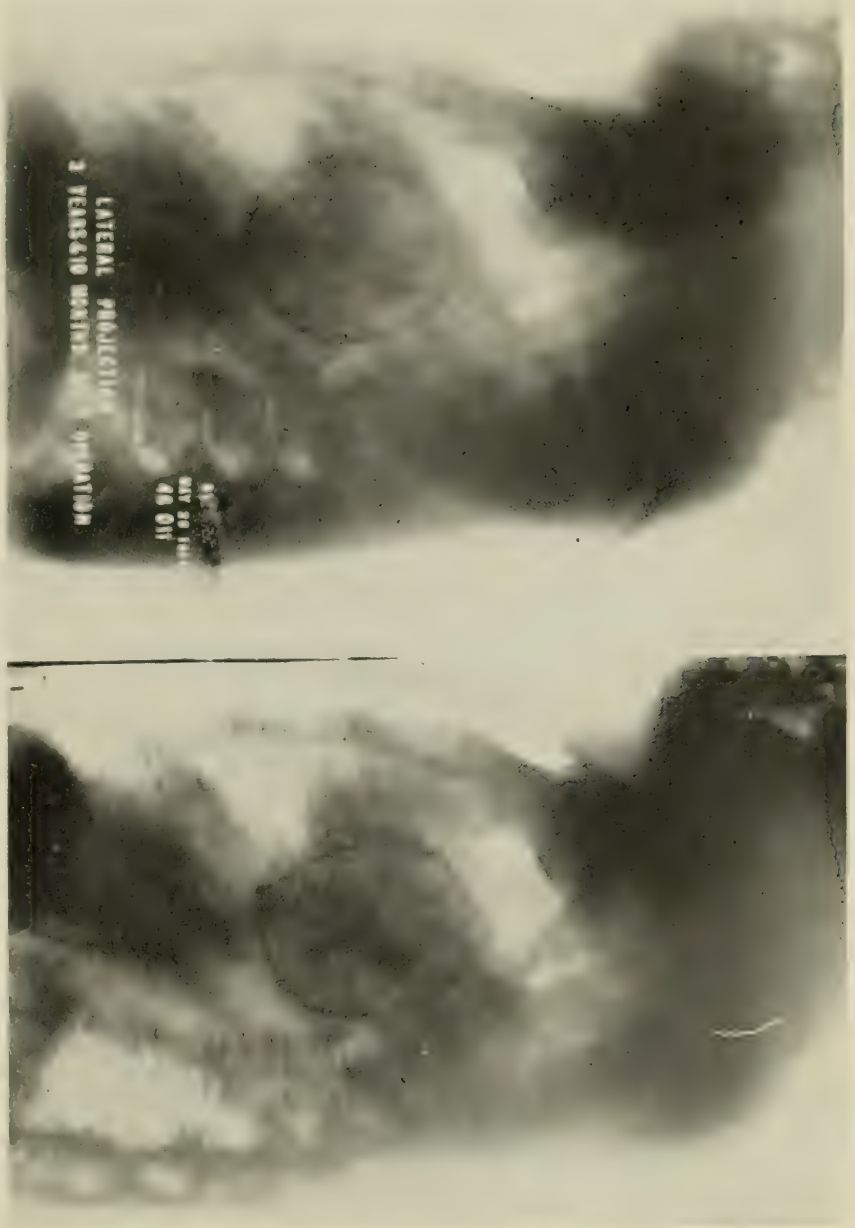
Patient G. S., May 28, 1916, Stereoscopic X-ray of the wire, viewed from the side. Size for hand stereoscope (Taken by Dr. Leon T. LeWald.)
